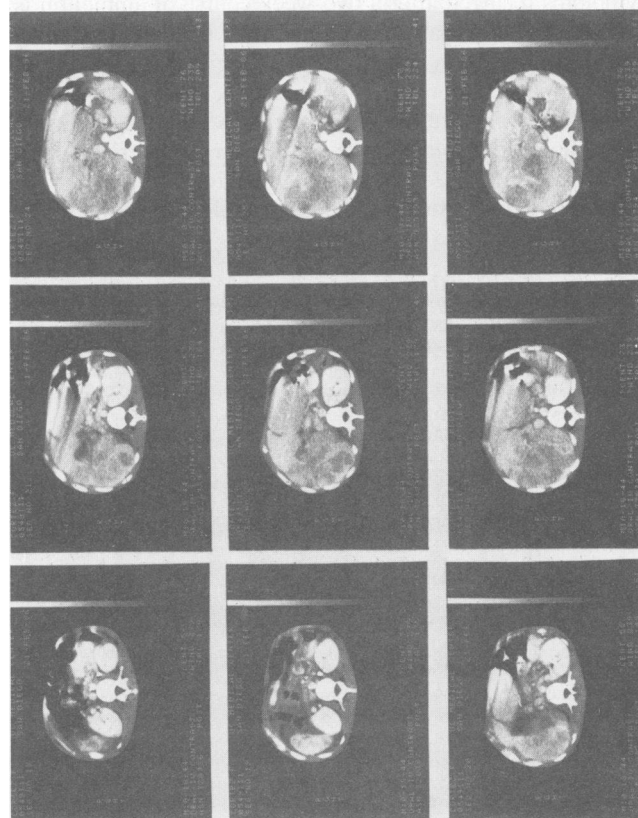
An abdominal computed tomographic scan shows multiple hypodense masses throughout the right lobe of the liver.
